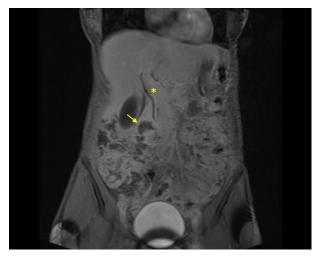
Coronal MRI: duodenal diverticulum (arrow) and moderate bile duct dilatation (asterisk).
